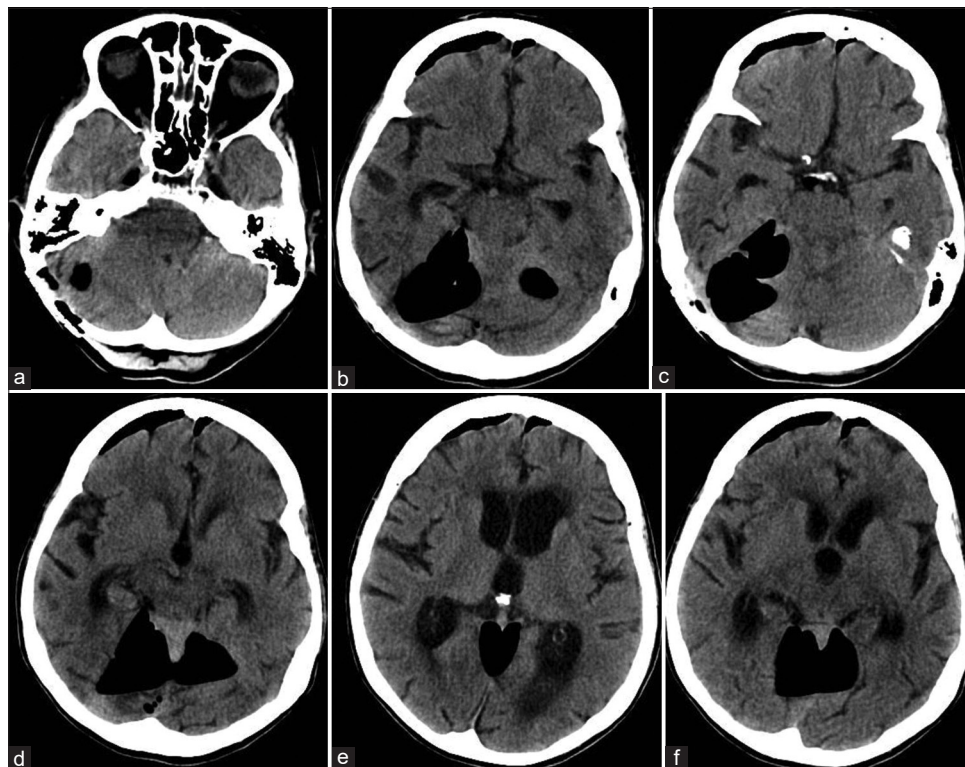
Tension pneumocephalus after repeat microvascular decompression. (a-f) Respectively, caudal to rostral serial computed tomography images of the head without contrast material obtained preoperatively showing significant pneumocephalus in the posterior fossa in the previous microvascular decompression surgical corridor as well as the bilateral inferior frontal areas.
